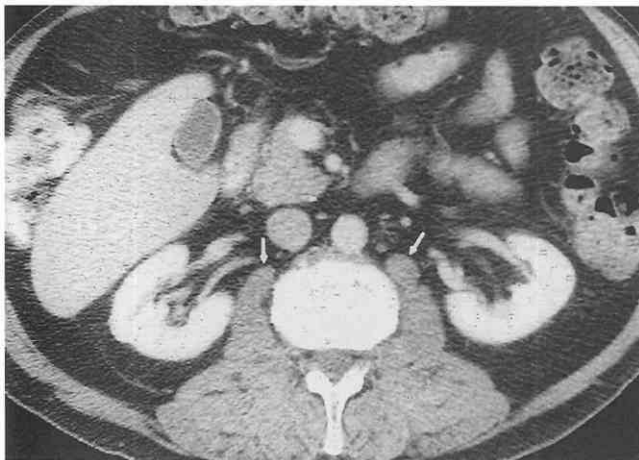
Psoas minor muscles. On this contrast-enhanced CT scan, the psoas minor muscles are identified as small masses (arrows) immediately anterior to the psoas major muscles. The right psoas minor is fused with the psoas major, which is the case in many patients. The left psoas minor muscle appears more discrete.
